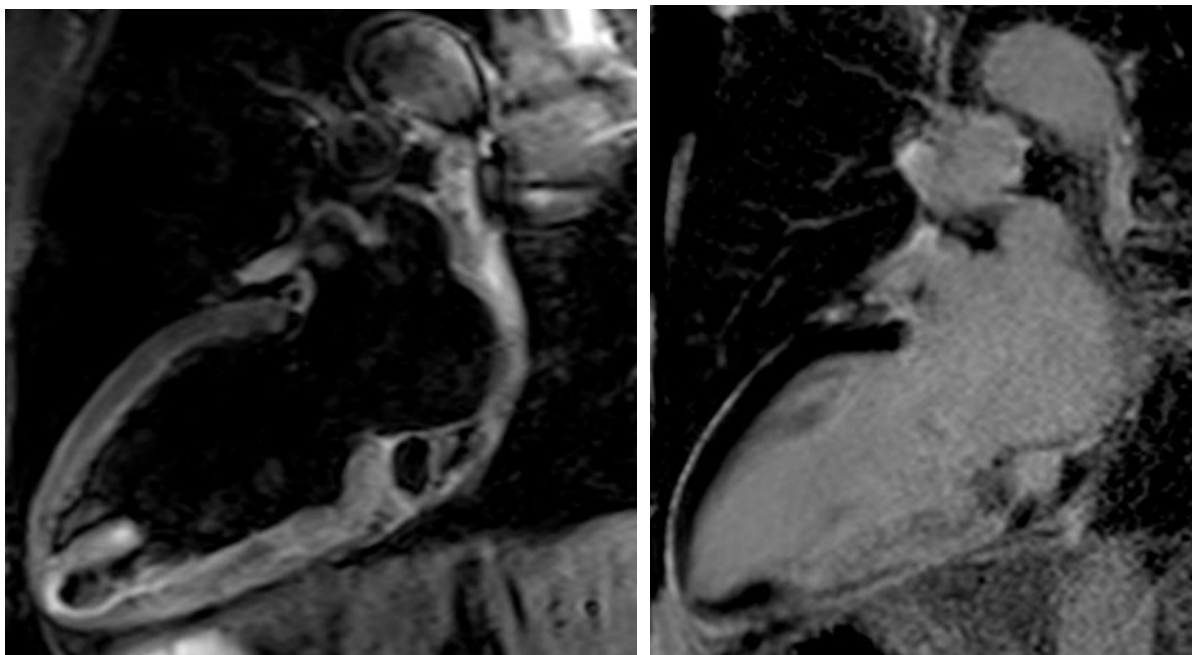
Examples of viability assessment MRI pictures. Left: *T2* weighted (after an inferior wall infarction); Right: *LGE*.
